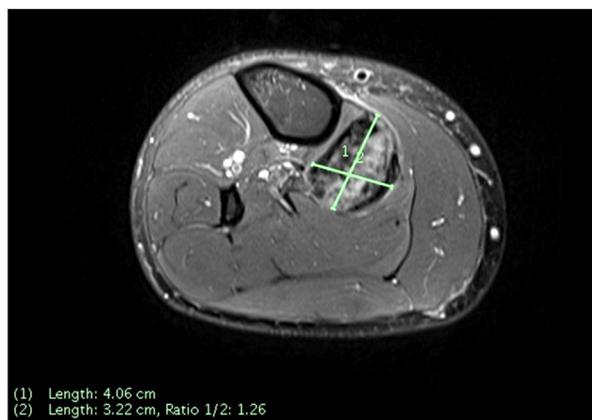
MRI image transverse calf.
